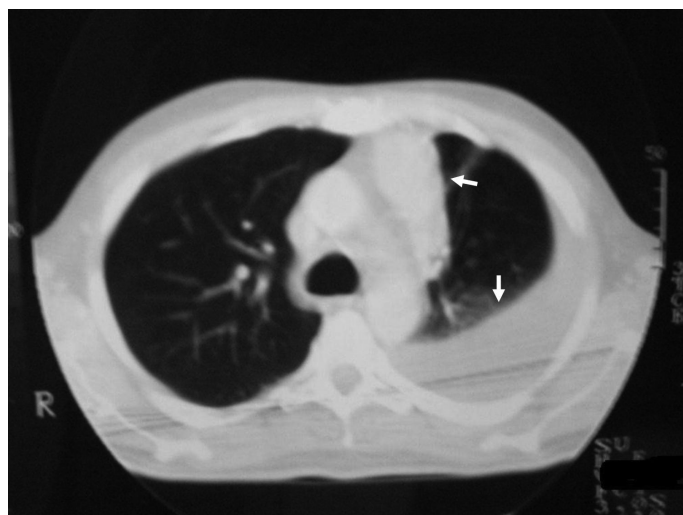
A thorax computed tomography showing the left pleural effusion and the atelectasis of the left upper lobe (arrows). It is shown the different intensity in the opacity of atelectasis in comparison with the pleural effusion.
